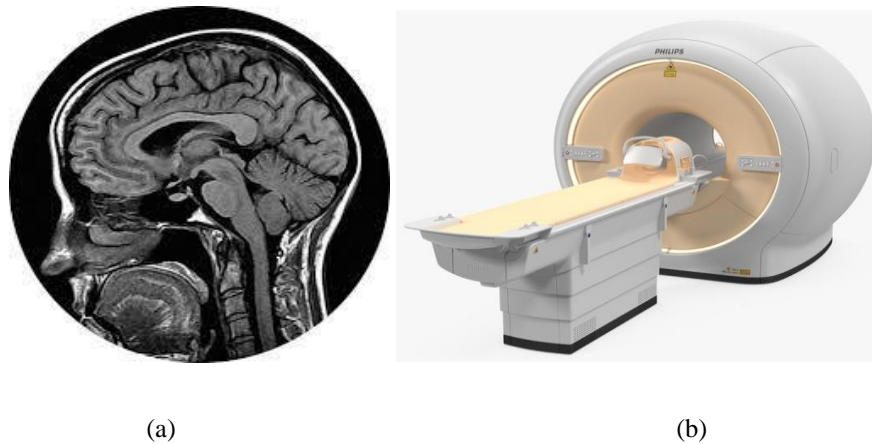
Magnetic Resonance Imaging (MRI) images: a) MRI brain scan and b) MRI scanner.
